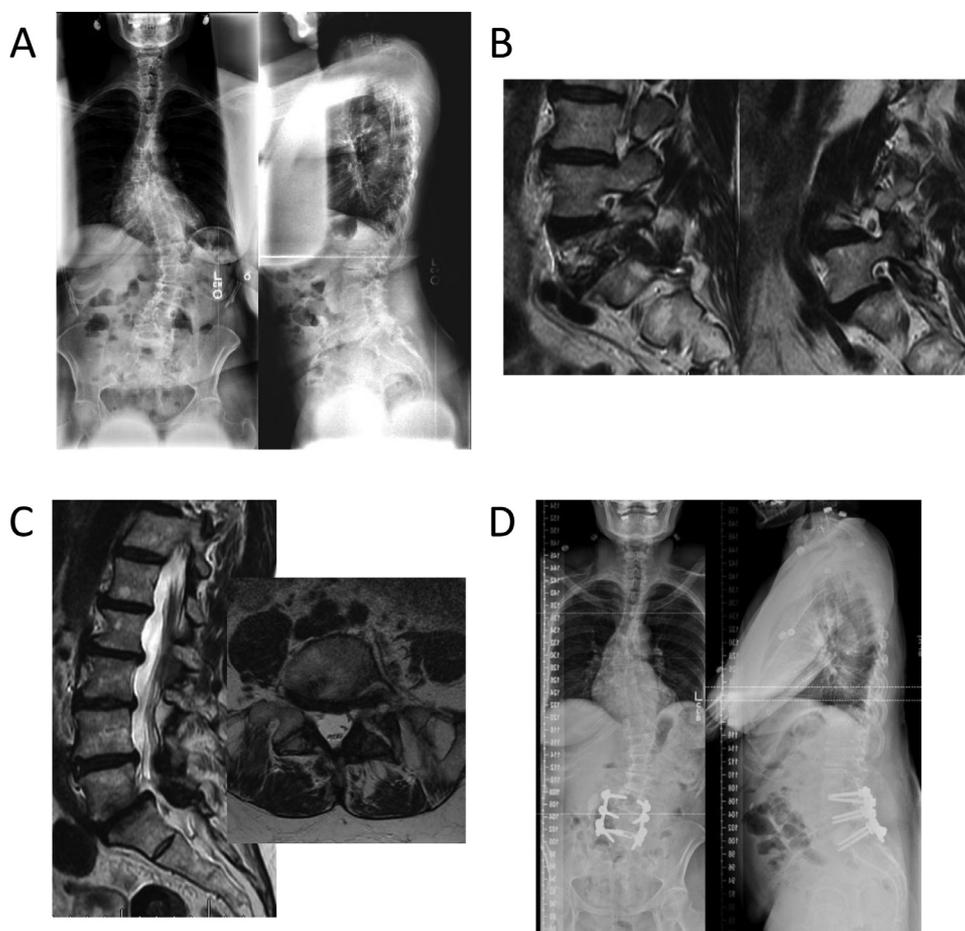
Preoperative standing scoliosis images (A) and the preoperative magnetic resonance imaging (B and C) of a 70 years old female with degenerative scoliosis with worsening back and left leg pain for 2 years. On exam, she had L5 distribution numbness and weakness. Magnetic resonance imaging showed severe stenosis of the left L5/S1 foramina in the concavity of the fractional curve and mild stenosis in the right L5 foramina (B and C). A transforaminal epidural steroid injection was performed at the L5/S1 level resulting in complete although temporary symptom relief. She underwent a limited posterior decompression and fusion with interbody placement (D). Post-operatively she did well with complete relief of her leg symptoms and improvement in her back pain. Clinical pearls: Limited coronal and minimal sagittal plane malalignment (Cobb angle 28° with minimal lateral listhesis, SVA 0 cm, PT 13°, LL 54°, PI 58°, PI-LL 4°). Given that symptoms were localized to the lumbosacral region, she was decompressed centrally with a laminectomy with direct and indirect decompression of her left sided nerve root through a foraminotomy and interbody placement at the L5/S1 level via left-sided TLIF (D).
